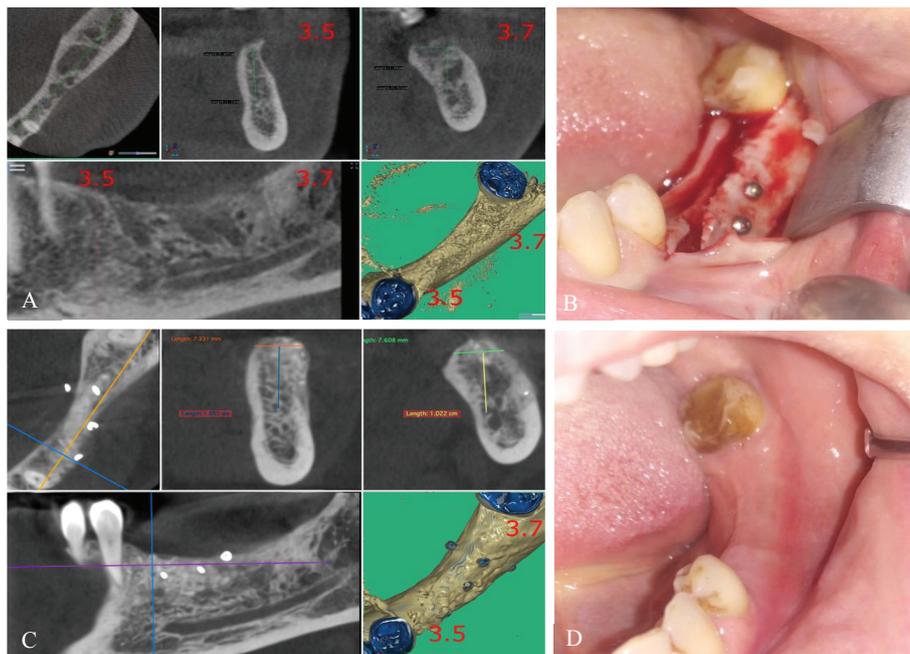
Stages of mesial RS: A – CBCT before the operation, multi-planar and 3D reformation; B – The step of operation: cortical block is splitted and shifted vestibularly; rotation axis vertical and distal. The displaced block is fixed by microscrews to the lingual plate; C – 4 months post op; D – Intraoral view 4 months post op
